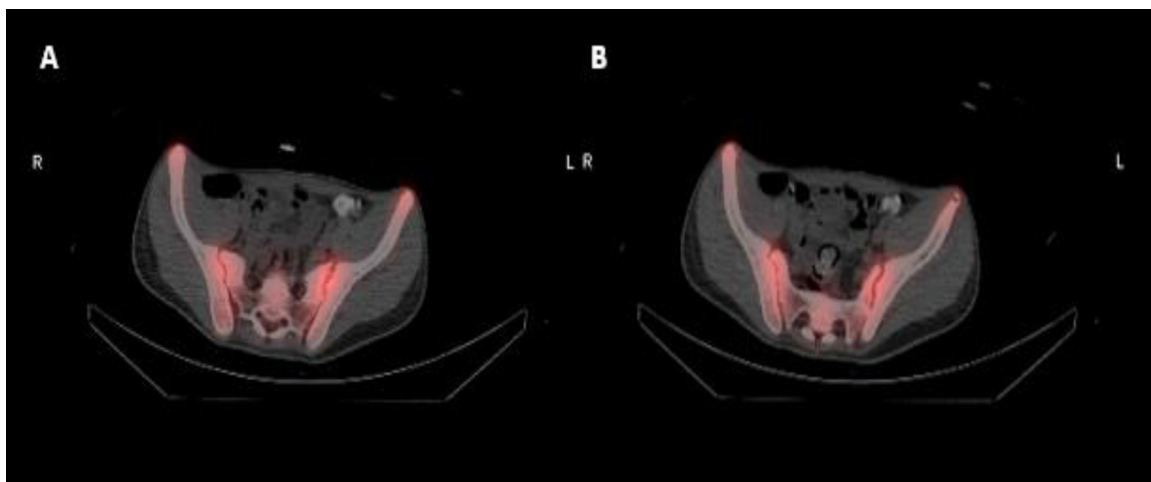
Single-photon emission computed tomography (SPECT) bone scan showing asymmetrical tracer uptake in the sacroiliac joints, slightly greater on the left side.
